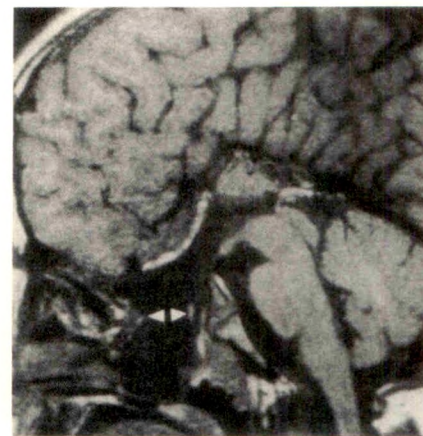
Sagittal SE 600/20 MR image of patient with sphenoidal encephalocele. The defect in skull base is seen as a CSF-intensity structure extending through skull base (arrowheads). Note associated agenesis of corpus callosum.
